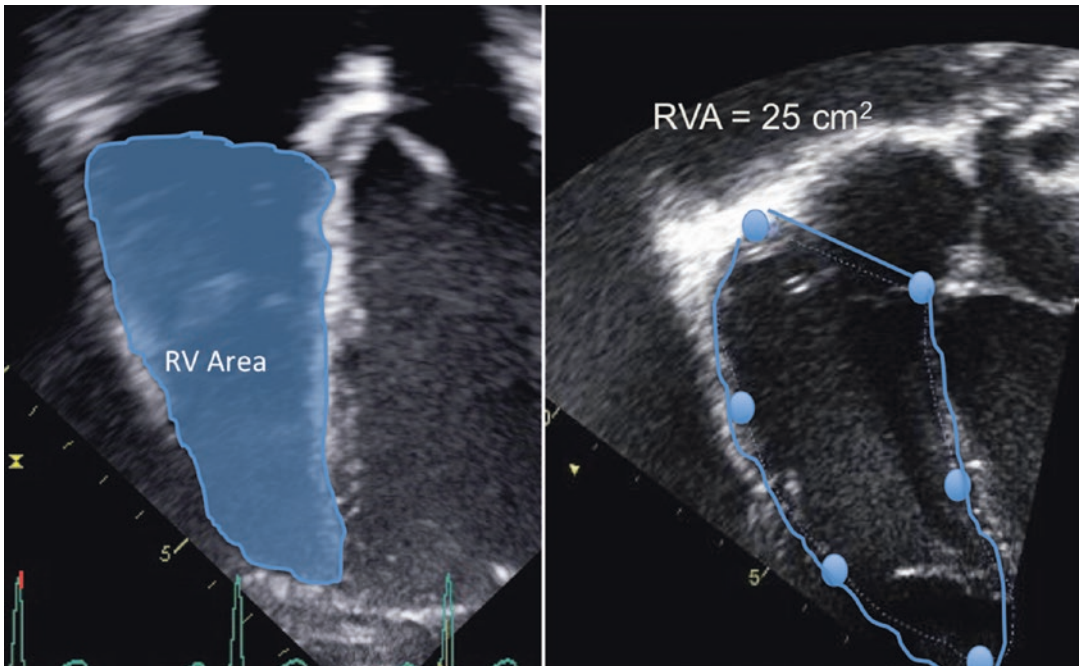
Measurement of end-diastolic RV area from the RV-centric apical 4-chamber view. The *right panel* shows the measurement in post-operative TOF patient. The area indexed for BSA was $29 \text{ cm}^2/\text{m}^2$
